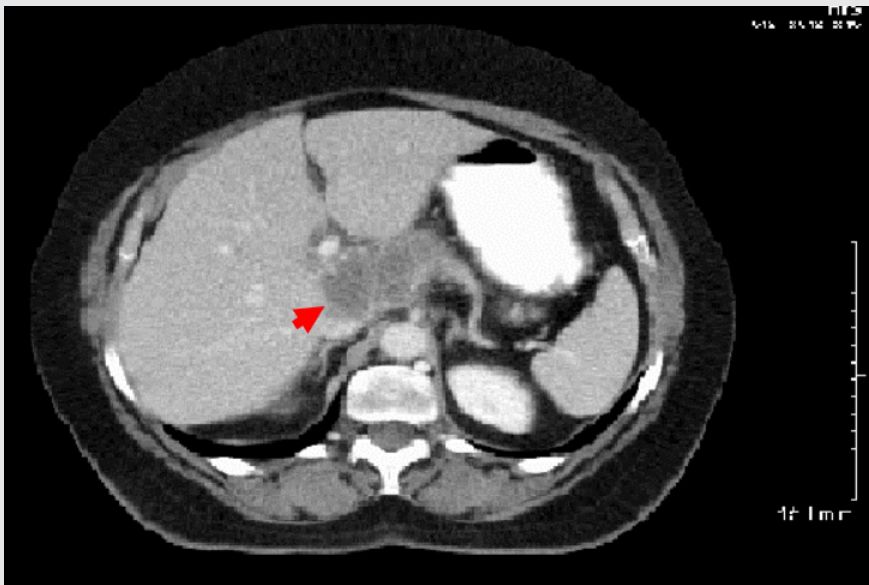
CT visualization of a liver lesion (red arrow) located deep within the caudate lobe.
